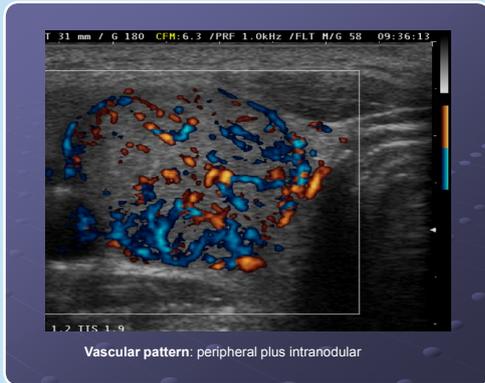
Color-doppler ultrasound of the nodule before LTA (4 fibers, 4 W, 1800 Joule)
